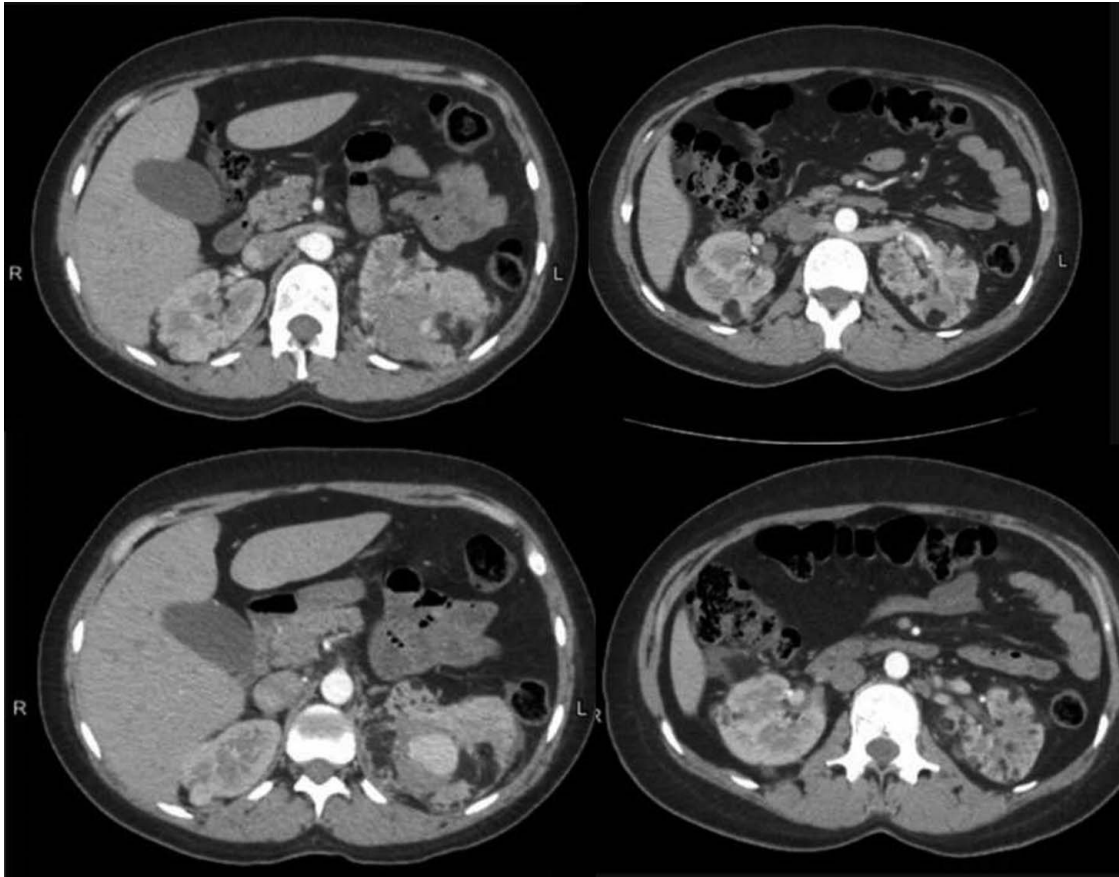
Abdominal computed tomography scan of the patient showed that both kidneys were enlarged and contained innumerable predominantly fat-density nodules consistent with multiple angiomyolipomas. In addition, there is mild bilateral perinephric stranding at the mid to lower pole.
